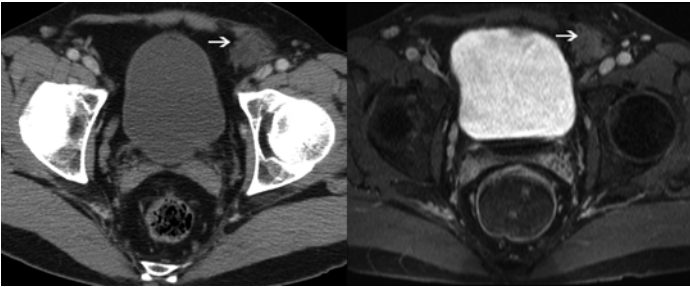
Contrast-enhanced axial CT and corresponding contrast enhanced T1-weighted axial MR images of mesh plug within the left direct space. Both modalities reveal a large “mass” (*white arrows*) with similar density/intensity as soft tissue. This appearance is due to incorporation of soft tissue within the mesh plug’s interstices. Though there is mild irregularity within the plug, the lack of contrast enhancement and normal appearance of the surrounding fat confirms lack of mesh pathology.
